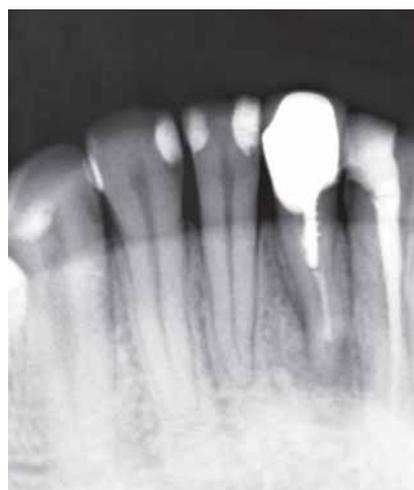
Radiograph showing endodontic failure with 24
